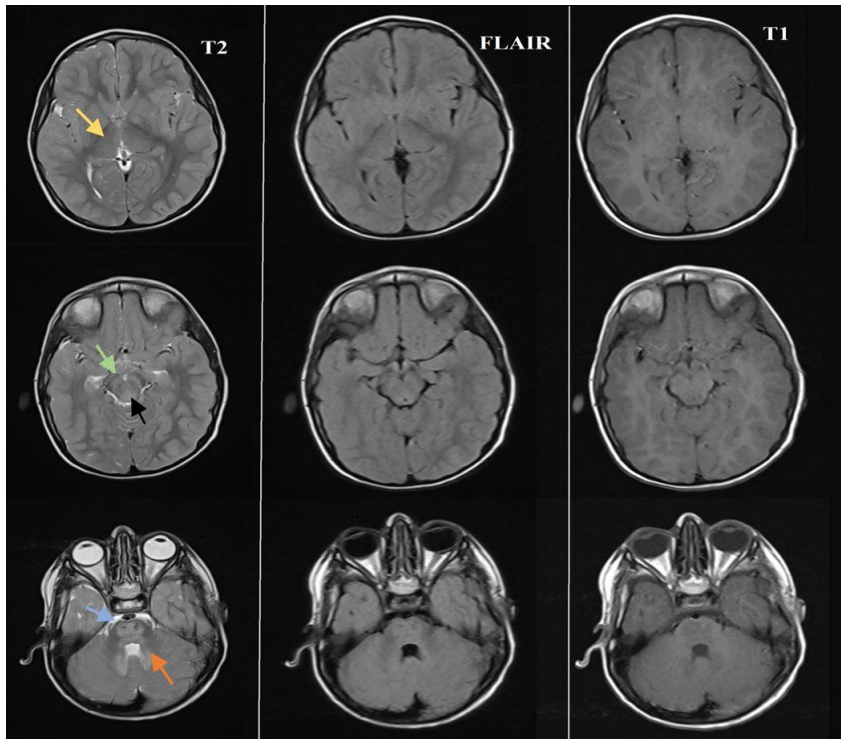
Brain MRI of the Patient at the Age of Five Years. Axial T2 Weighted and Flair Images Reveal Symmetrical Hyper Intensity Of Medial Thalami (Yellow Arrow), Periventricular Matter of Third Ventricle and Pulvinar, With Sparing of the Mammillary Bodies, Fornices, Internal Capsule, and Corpus Striatum. The signal Abnormality Extends to the Midbrain (Green Arrow) and Pons (Blue Arrow), with Involvement of Red Nucleus and Substantia Nigra and Periaqueductal Gray Matter and Tegmental Tract (Black Arrow) and Dentate Nucleus (Orange Arrow) with Sparing of Most of the Corticospinal Tract and Middle Cerebellar Peduncle. In this region, the T1 Sequence Showed a Faint Decreased Signal Intensity
